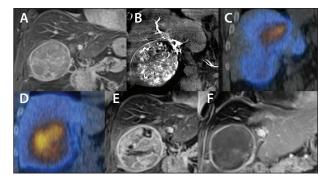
Pretreatment, delayed phase images of the solitary 8.5-X 8.1-cm HCC tumor within segment 5/6 (A). CBCT demonstrated complete coverage of the tumor from the location of the microcatheter where the MAA and future Y90 was to be administered from (B). Tc99m MAA SPECT/CT confirmed the complete coverage of the targeted tumor within the targeted right lobe and absence of extrahepatic activity (C). Y-90 bremsstrahlung SPECT/CT confirmed the complete coverage of the targeted tumor and absence of extrahepatic activity (D). Posttreatment MRI delayed phase images at 4 weeks demonstrated > 50% tumor necrosis/response (E). Posttreatment MRI delayed phase images at 6 weeks after the second stage of therapy demonstrated complete response without recurrence of disease (F).
